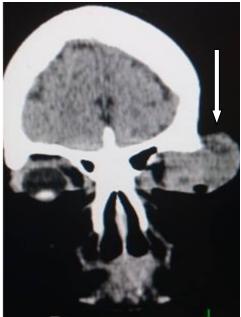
CT coronal slice showing same soft tissue mass in the left eye lid (white arrow)
